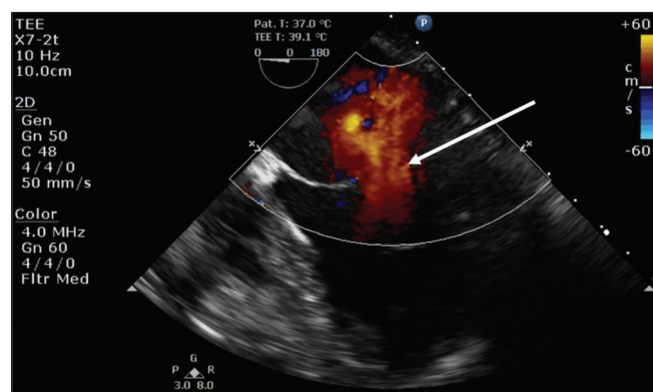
Mid-esophageal four-chamber transesophageal echocardiography still image demonstrating severe mitral regurgitation (arrow)
